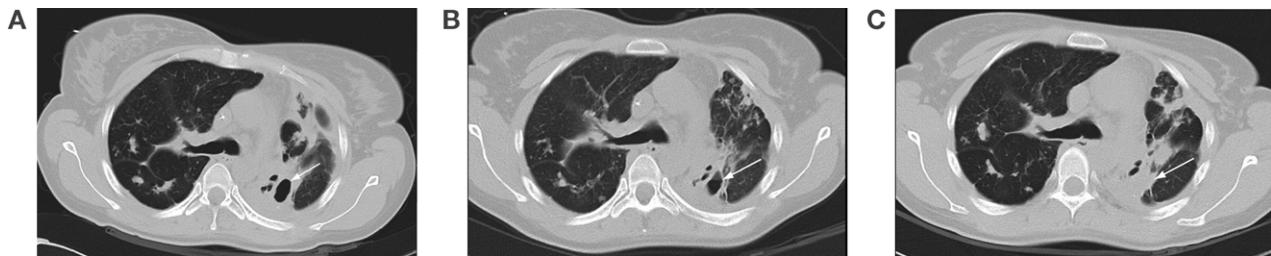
Chest CTs clearly showing changes in the cavity in the LUL. A. CT scan 2 months before second EBV implantation (November 2011). The size of the cavity in the LUL had remained stable (2.1×1.2 cm) since the CT scan taken in June 2011 (see Figure 1B). B. 1-month follow-up CT scan (February 2012) showing a reduction in the size of the cavity (1.7×1.0 cm) in the LUL (arrow). C. 10-month follow-up CT scan (October 2012) showing resolution of the cavity (EBVs still in place). CT = computed tomography; LUL = left upper lobe; EBV = endobronchial valve.
